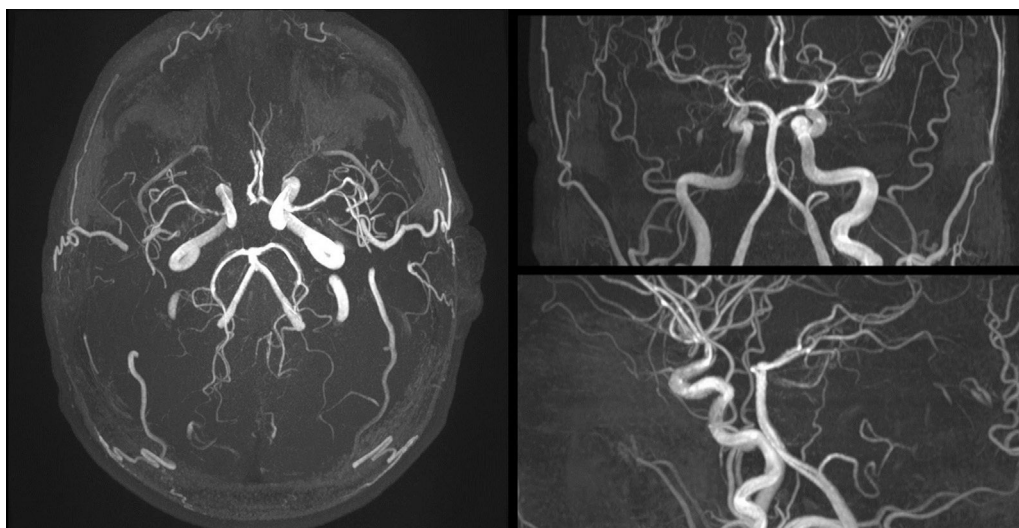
MRI angiogram image. Severe stenosis of the right terminal internal carotid artery and right M1 segment. Possible occlusion of the right A1 segment.
